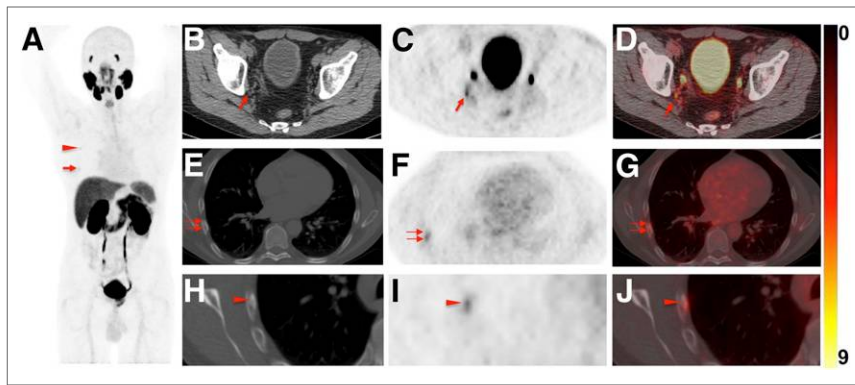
Images of 60-y-old man undergoing ^{18}F -DCFPyL PET/CT for primary diagnostic assessment (prostate-specific antigen level on date of scan, 13.5; no previous therapies). (A) Whole-body maximum-intensity projection demonstrates multiple sites of suggestive radiotracer uptake (e.g., third right rib [arrowhead] and sixth right rib [arrow]). (B–D) Axial CT (B), axial ^{18}F -DCFPyL PET (C), and axial ^{18}F -DCFPyL PET/CT (D) show mild radiotracer uptake in right iliac LN (arrow). Although ER trained on ^{18}F -DCFPyL PET called this lesion PSMA-RADS-4, the 2 remaining readers trained on ^{68}Ga -PSMA PET called it PSMA-RADS-3A (i.e., suggestive but indeterminate LN) (12). One might speculate that ^{18}F -trained reader had higher confidence in lesion interpretation on ^{18}F -DCFPyL PET scans because of higher sensitivity in detection rate of small lesions using ^{18}F -labeled radiotracers than using ^{68}Ga -PSMA (27). (E–G) All 4 readers classified overall scan impression as PSMA-RADS-5, because CT (E) revealed findings corresponding to sixth right rib metastasis, with discernible radiotracer uptake on axial ^{18}F -DCFPyL PET (F) and axial ^{18}F -DCFPyL PET/CT (G) (doubled arrows). (H–J) Magnification of this sixth-rib suggestive site of uptake provided in axial CT (H), axial ^{18}F -DCFPyL PET (I), and axial ^{18}F -DCFPyL PET/CT (J) further suggested this to be malignant lesion at this uptake site (arrowhead).
